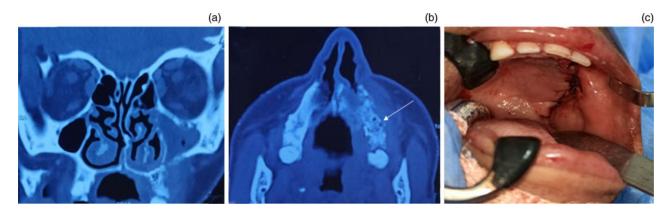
Case 3. Contrast-enhanced computed tomography of the nose, paranasal sinuses and orbit in the (a) coronal and (b) axial view. White arrow indicates left-sided hard palate erosion. (c) Intra-operative image after closure.
